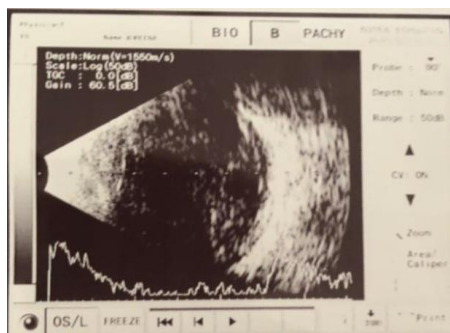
Ocular ultrasound showing opacity in the vitreous body indicating endophthalmitis
